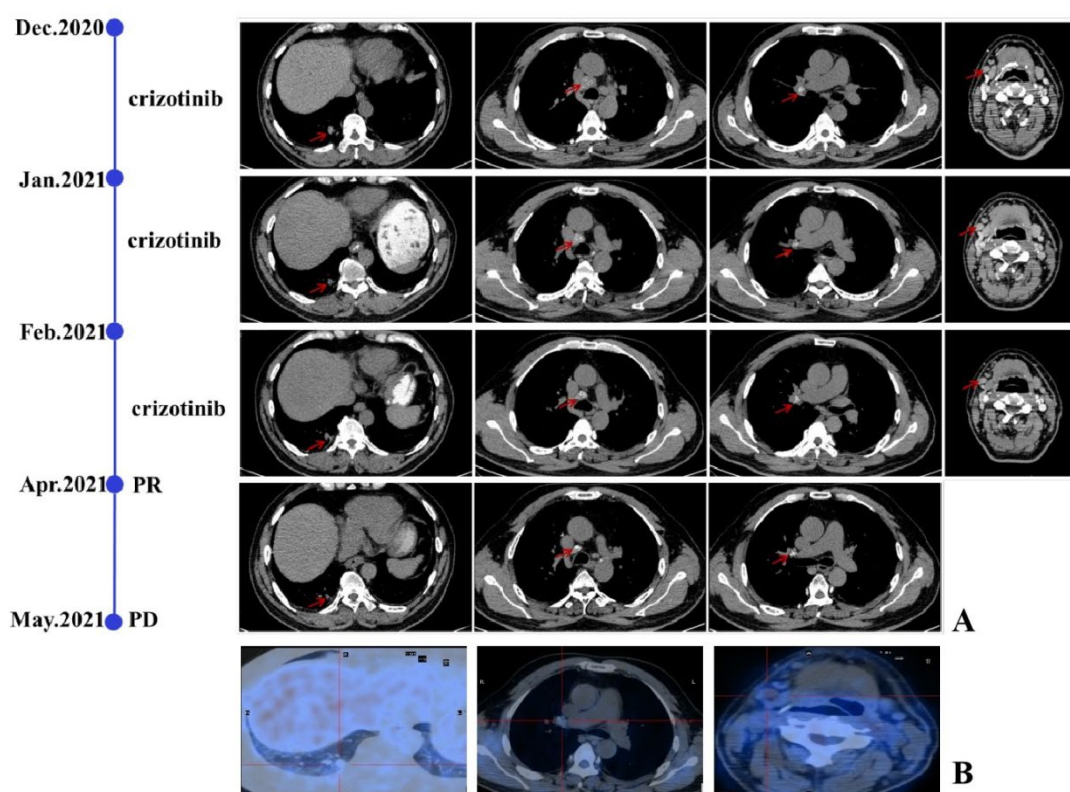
Radiological evaluation before and after therapy. (A) The CT scan images demonstrated reduction in pulmonary lesions, the evaluation of the status of disease was PR after 1 month and 4 months (7.56 mm × 3.2 mm) vs. therapy before (12.7 mm × 10 mm). (B) PET-CT showed the reduction of targeted lesion, including nodule in the right lung lobe and cervical lymph nodes. PR: partial response. PD: progressive disease.
